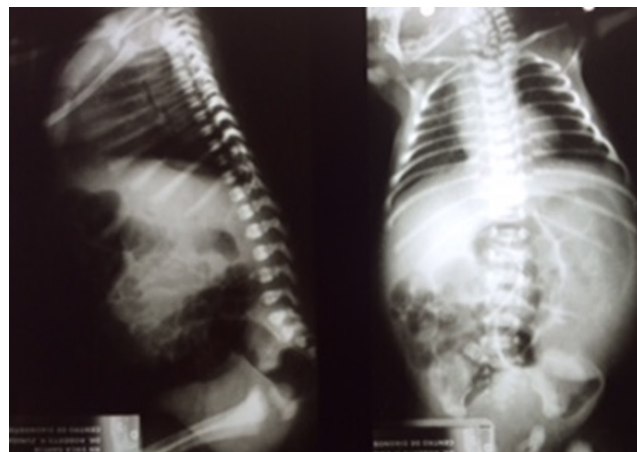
AP and lateral radiographs of the chest and abdomen in which poor air distribution is observed inside the abdomen with probable gastric enlargement
